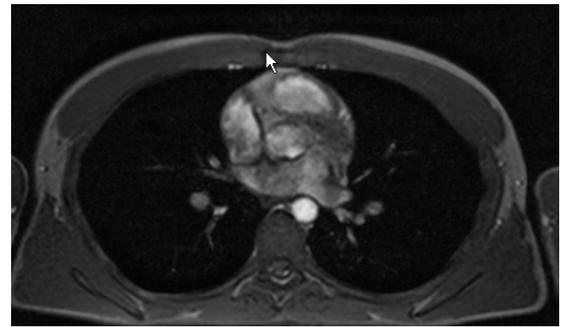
MRI slice of a human heart.
